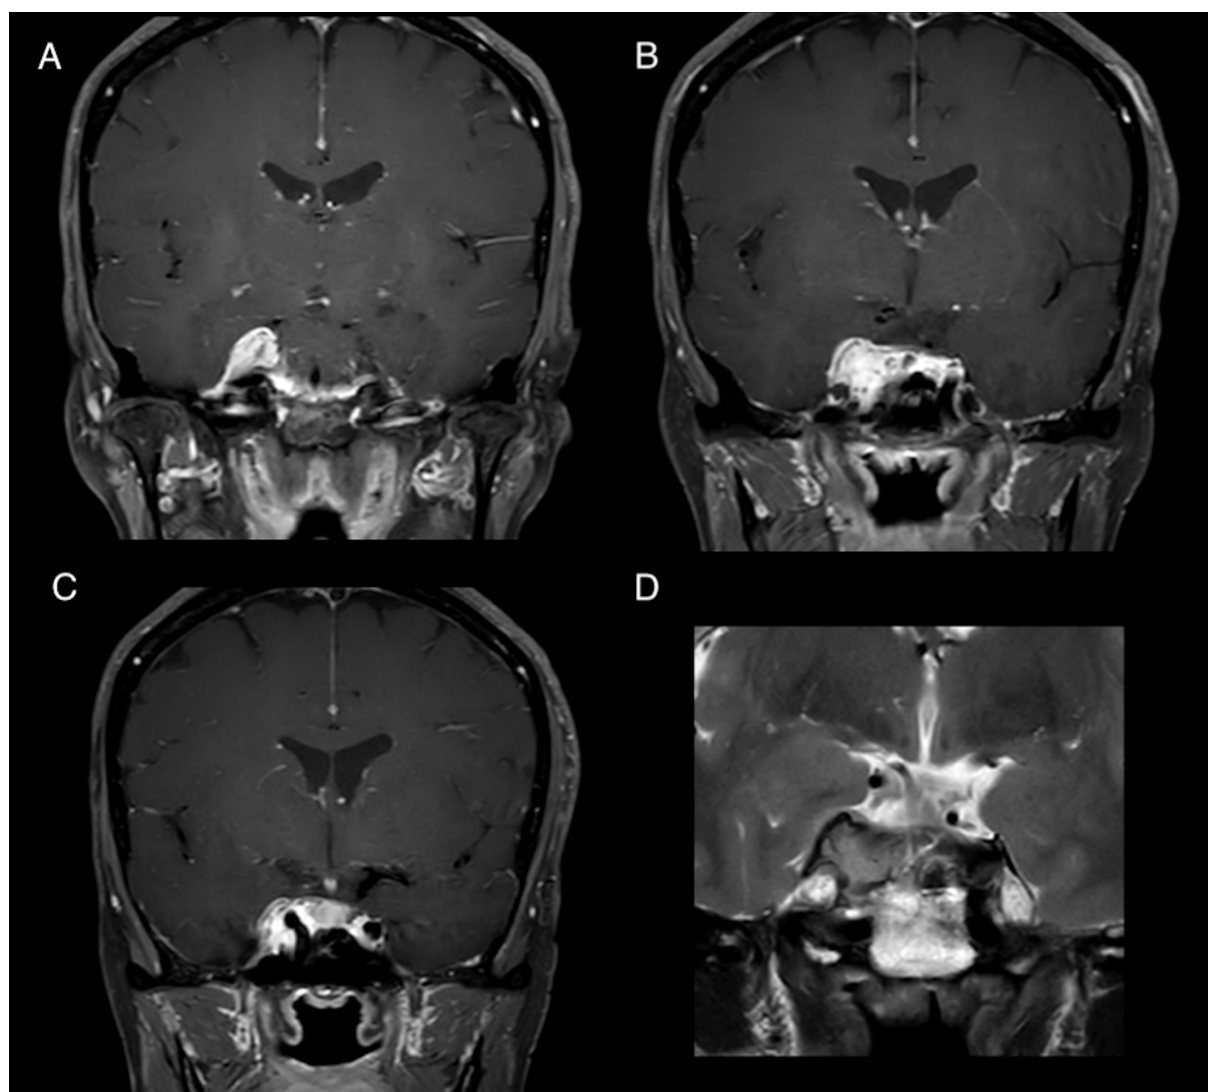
Coronal view of a cerebral MRI showing a meningioma in the right CS. The asymmetry between the row cavernous sinuses is evident and the lesion present a strong contrast enhancement after gadolinium administration (A-C). The relationships between the meningioma and the lateral wall of the CS and the optic apparatus are better defined through the analysis of T2-weighted sequences (D). CS: cavernous sinus
